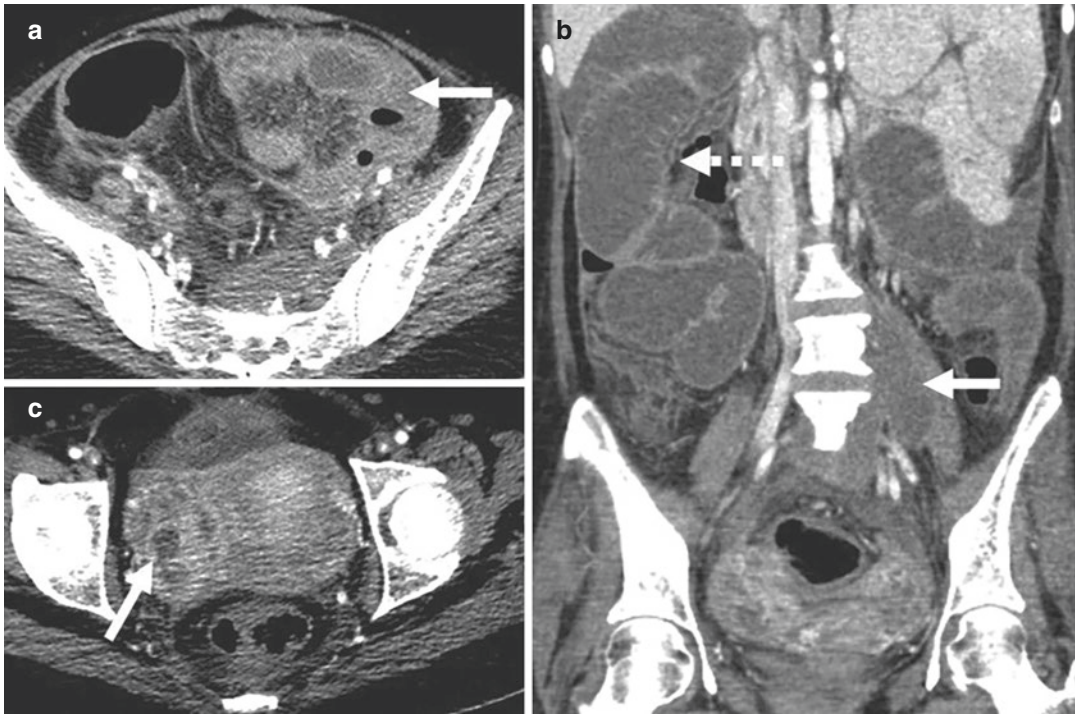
Disseminated tuberculosis of the abdomen in a 31-year-old woman presenting with low-grade fever and abdominal pain for 2 weeks. She also has diabetes mellitus. (a and c) Axial and (b) coronal contrast-enhanced CT images show (a) clumping of small bowel with mesenteric
